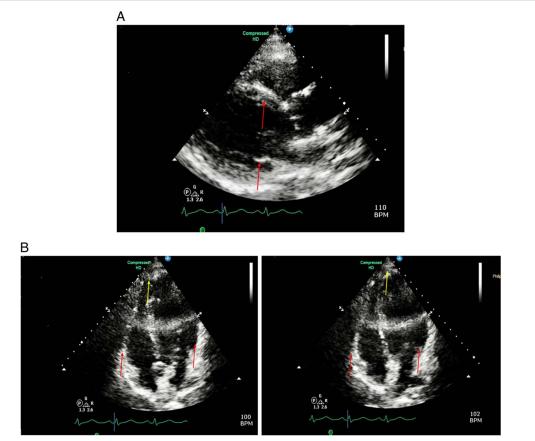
Transthoracic echocardiogram. (A) Para-sternal long axis view showing hypokinetic bases (red arrows). (B) Apical four-chamber view showing hyperkinetic apex (yellow arrows) and hypokinetic bases (red arrows).
